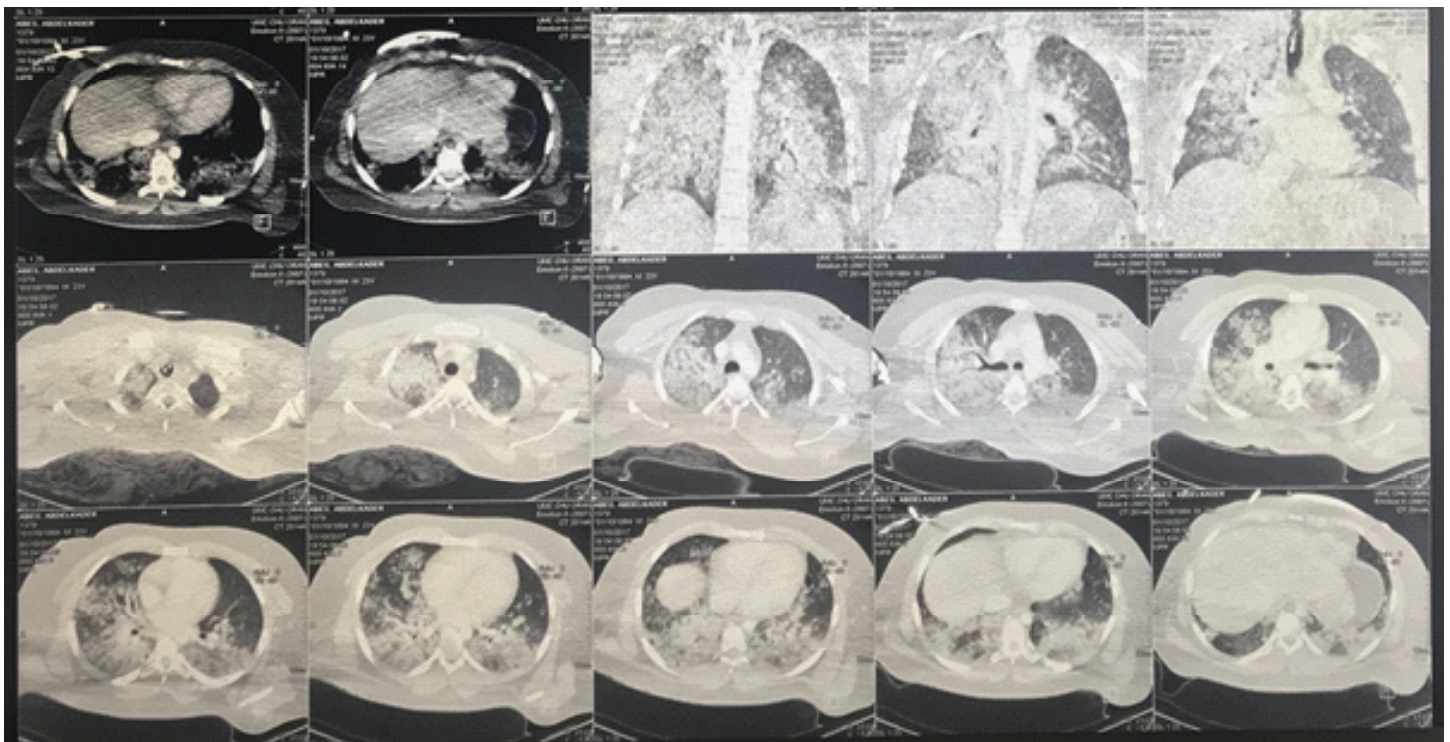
The thoracic CT scan.
